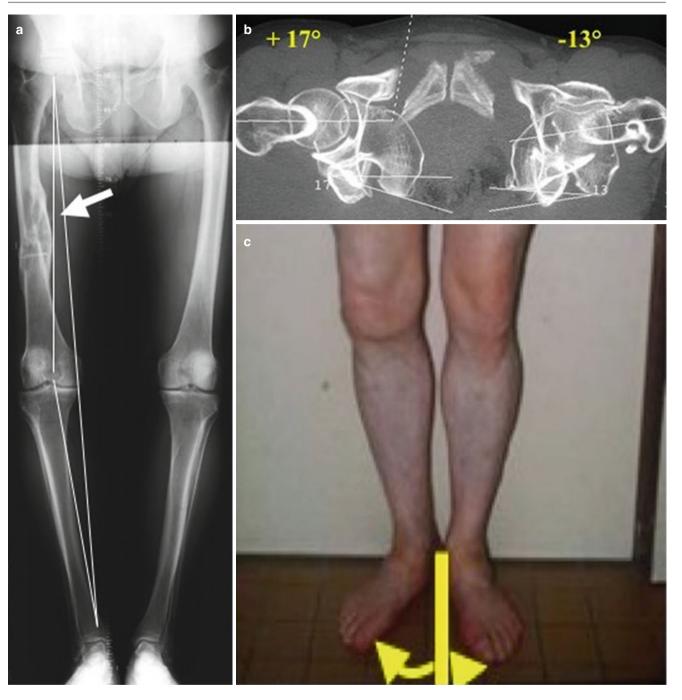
(a) Medial femorotibial osteoarthritis caused by rotational malunion after femoral fracture (external rotation of the right limb). (b) External rotational deformity measured by CT scan. (c) Clinical deformity
